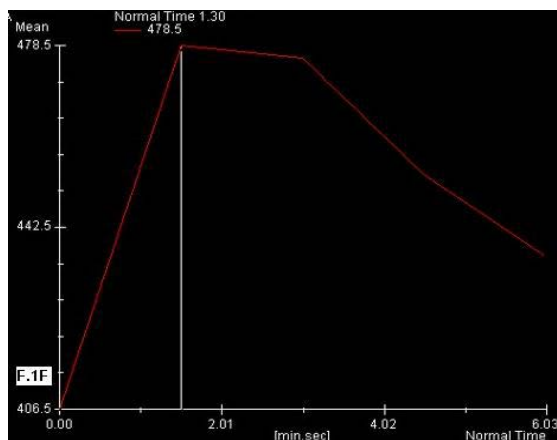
Neoplastic recurrence. 48 year-old female submitted to right quadrantectomy 2.5 years ago for invasive ductal carcinoma. (A) Axial T1WI & (B) Axial S1TR demonstrate a right breast ill defined mass at the surgical scar. (C) DWI with b= 800 shows a hyperintense mass (arrow). (D) ADC map shows hypointense lesion (arrow) with ADC value of about $1.09 \times 10^{-3} \text{ mm}^2/\text{s}$. (E) Post-contrast study displays marked enhancing mass. (F) dynamic curve shows washout curve with peak enhancement at 1.5 minute
